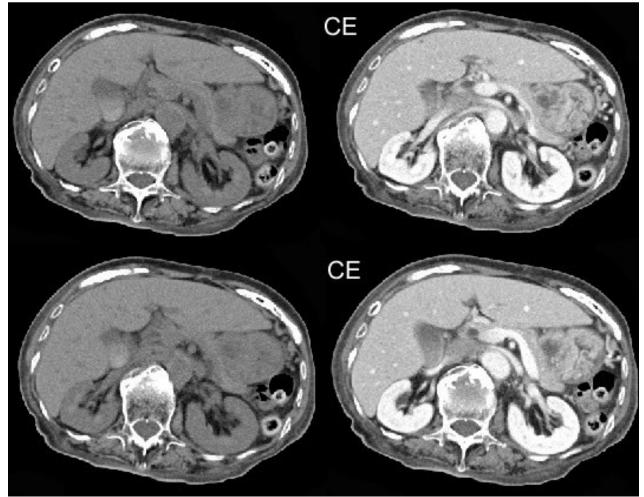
87 year old woman with neoplastic meningitis from gastric cancer. An abdominal CT scan showed irregular thickness of the gastric wall of the stomach near the body of the pancreas. The gastric wall was contrast enhanced (right panel). CE; contrast enhanced.
